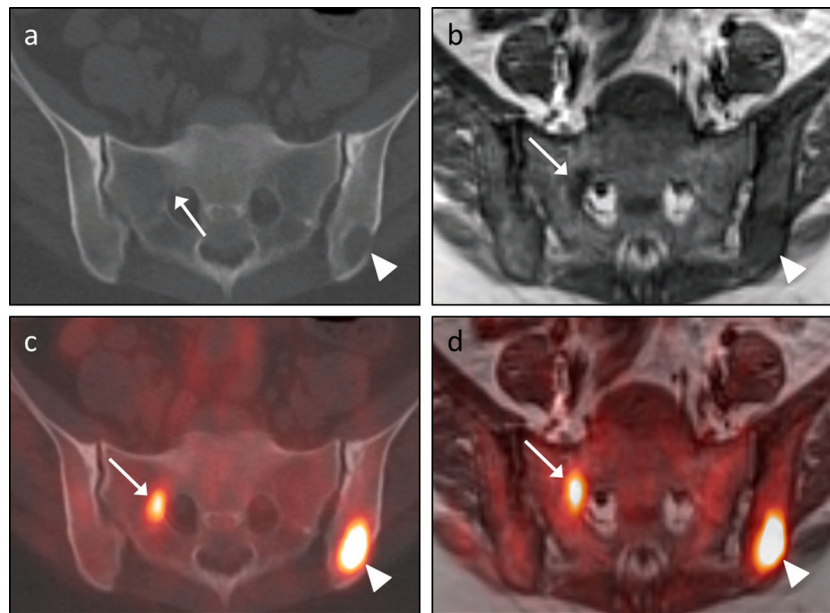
Advantage of MRI in depicting subtle marrow-replacing lesions. A 42-year-old man with epithelioid hemangioendothelioma of the right femur status-post percutaneous cryoablation presented for restaging and underwent both PET/CT (a – transaxial CT images; c – transaxial CT images with PET fusion) and PET/MRI (b – transaxial T1W TSE images; d – transaxial T1W TSE images with PET fusion). An FFBL within the left iliac bone (arrowheads in c and d) corresponded to an osteolytic lesion on the CT images (arrowhead in a) and an area of hypointense
